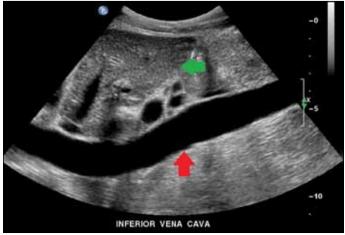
Ultrasound: longitudinal section of a normal IVC. Note the vessel is anechoic with no thrombus present (red arrow) posterior to the left lobe of the liver (green arrow).
